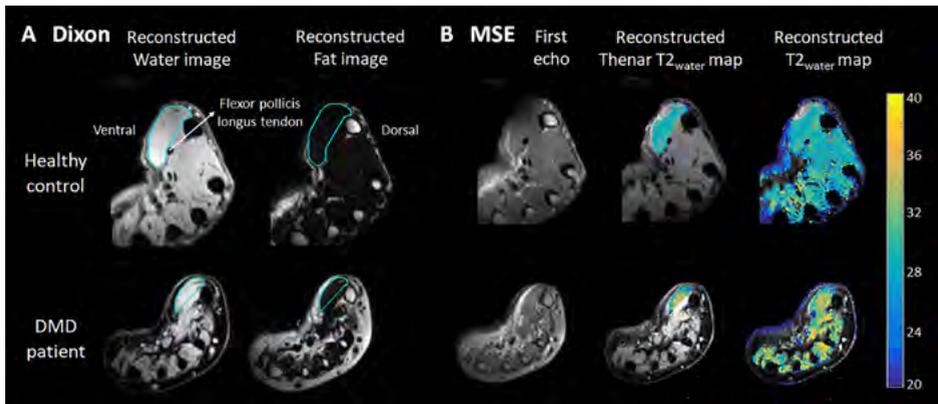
Dixon and multi-echo spin-echo (MSE) MRI acquisitions and analyses
